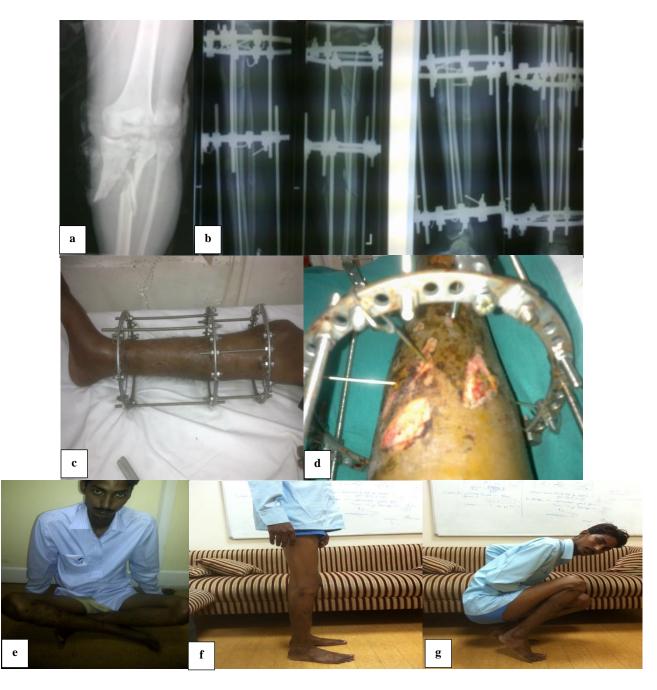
(a) Pre-operative X-ray; (b) post-operative X-ray; (c) extensive soft tissue injury evolving even after fixator application; (d) healed soft tissue component of injury by post-op day 10; (e-g) functional status of patient at final follow up visit.
